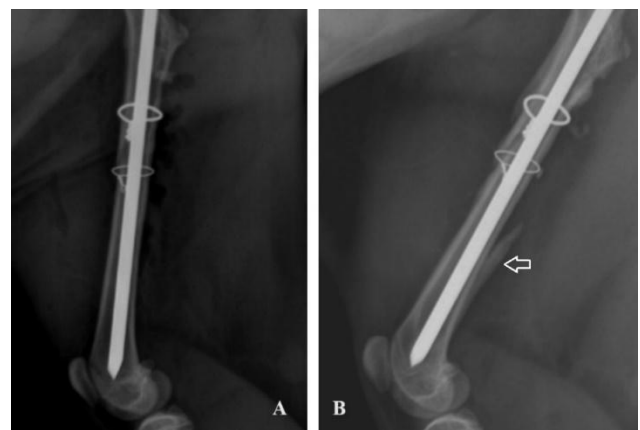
Postoperative 0th (A) and 20th (B) days radiographic images of Case 8. White arrow: callus.
